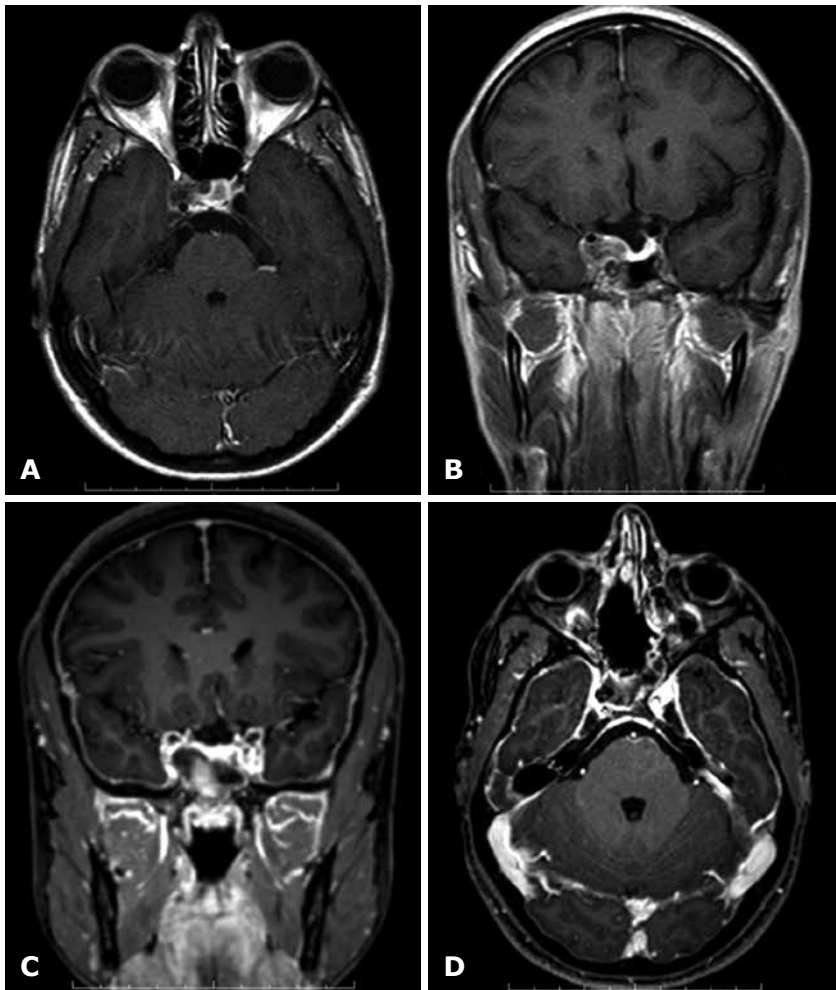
MRI scans with gadolinium of a petroclival tumor with the right cavernous sinus extension. A, B — preoperative axial and coronal T1 weighted images; C, D — postoperative axial and coronal T1 weighted images
